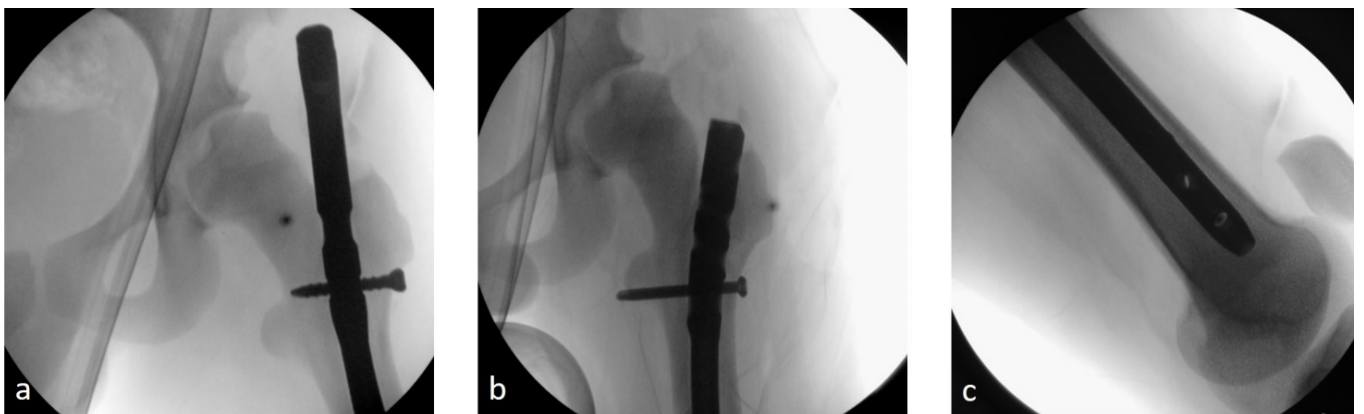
Intraoperative X-ray of the left femur: a) initial condition with proximal protrusion of the femoral nail and altered shape of the iliac bone; b) X-ray of proximal femur performed after positioning the new nail; c) X-ray of the distal femur performed after positioning the new nail.
